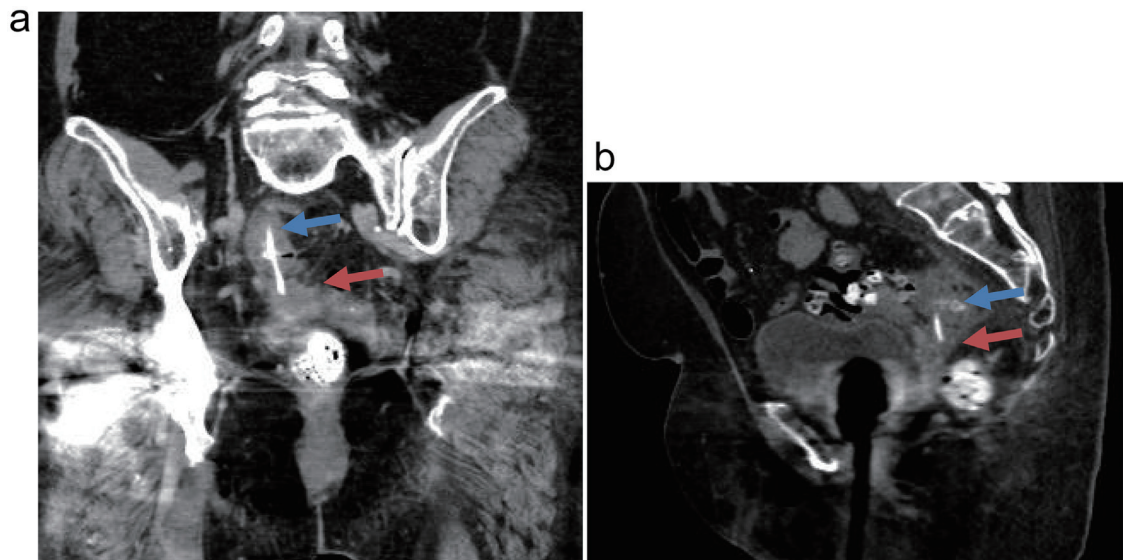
CT scan images. Coronal (a) and sagittal (b) CT images of the pelvis show a vertically oriented radiopaque foreign body within the sigmoid colon. The proximal tip of the foreign body is positioned within the sigmoid colon lumen (blue arrow), and the distal tip is within the uterus (red arrow). The foreign body traverses a thin band of intersecting pelvic fat.
